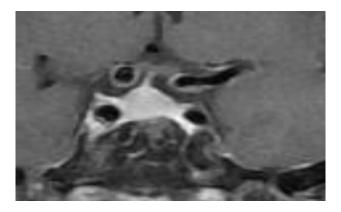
Coronal section T1 weighted post contrast enhancement of MRI brain showing bulky pituitary gland with homogeneous enhancement.
